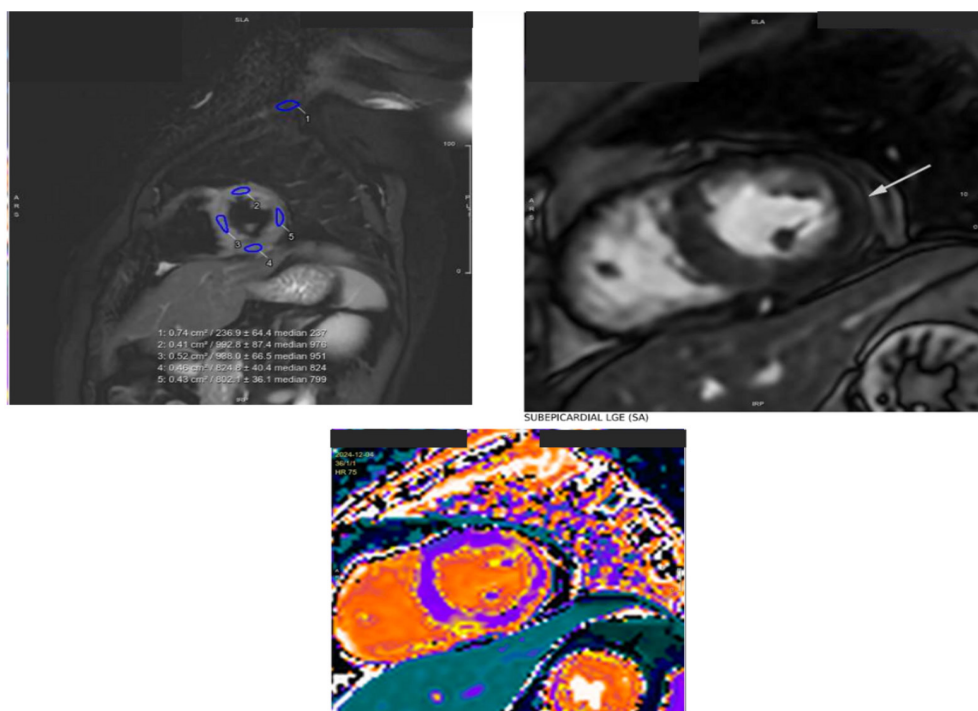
Cardiac magnetic resonance (CMR) images demonstrating myocardial inflammation. (Top left) T2-weighted imaging in all mid-segments of the left ventricle (LV) shows increased signal intensity consistent with myocardial edema (blue regions of interest). (Top right) Late gadolinium enhancement (LGE) was identified in the subepicardial region of the lateral wall (arrow), indicating myocardial injury and fibrosis. (Bottom) Native T1 mapping with elevated value in mid lateral segment, further supporting presence of myocardial edema. These findings fulfill the updated Lake Louise criteria and confirm the presence of acute myocarditis.
